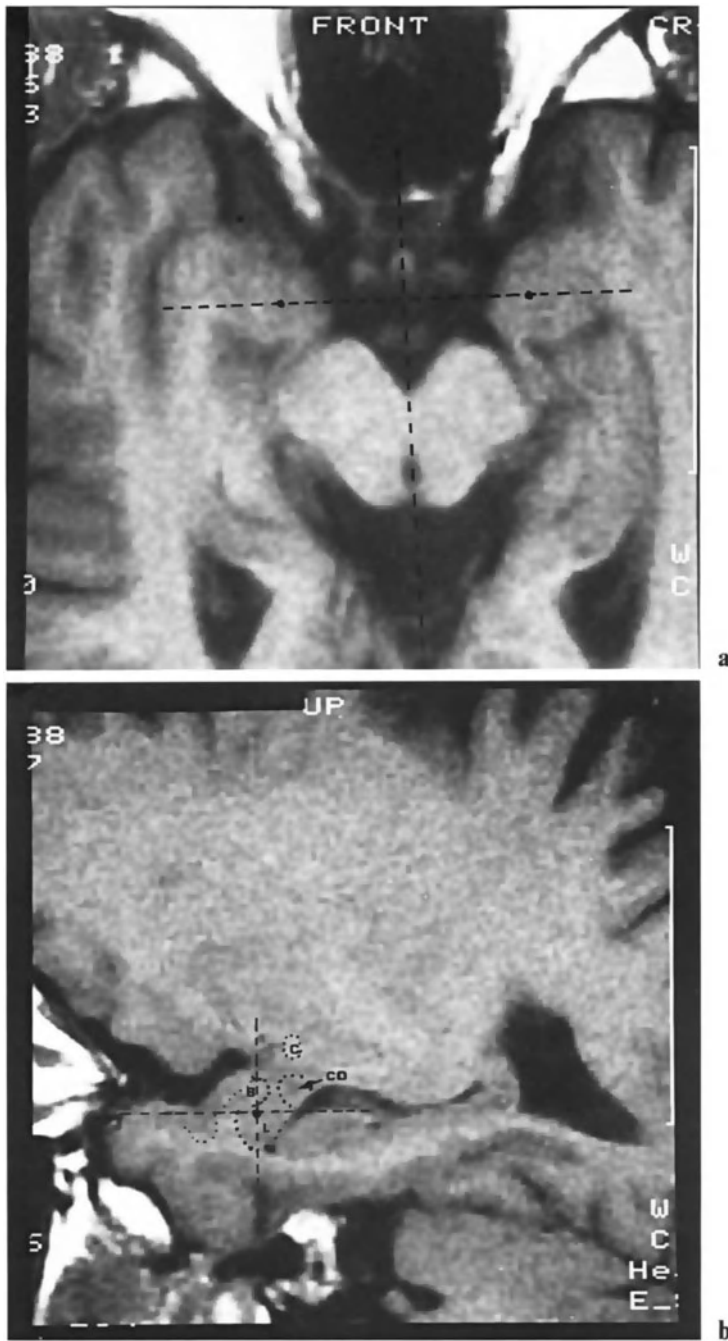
MRI targeting for amygdalotomy. (a) Axial incidence; (b) MRI localization – a parasagittal view, *C* commissura anterior, *CD* cauda nuclei caudati, *B* basal nucleus, *L* lateral nucleus
